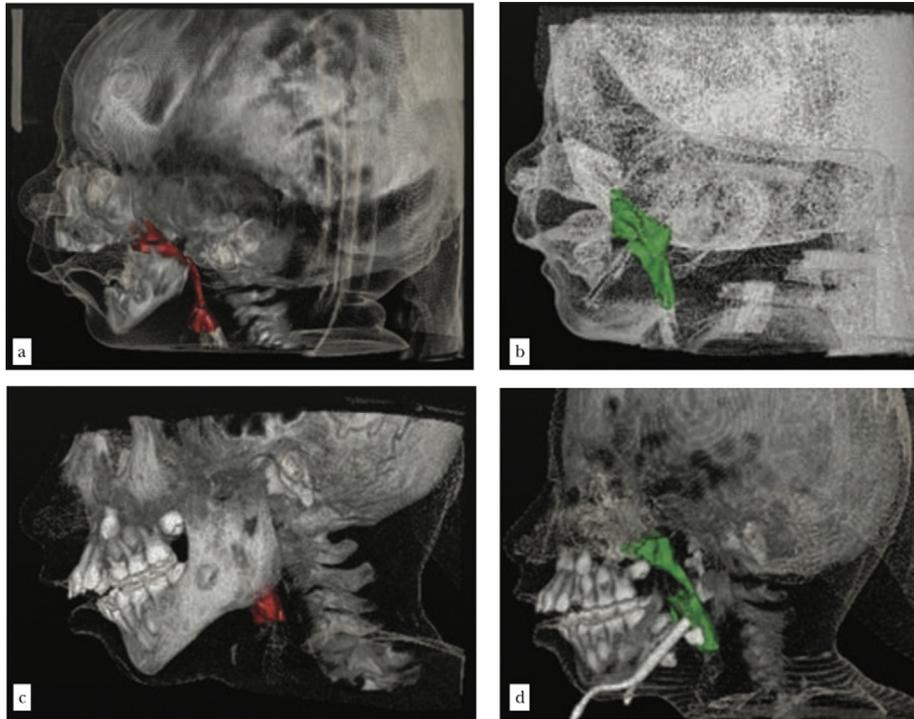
Patient number 3: (a) pre-operative and (b) post-operative virtual three-dimensional computed tomography scan showing soft tissue, skull, and airway reconstruction of a young boy affected by Crouzon syndrome, who experienced a post-operative upper airway volume gain of 28.586 mm³; patient number 6: (c) pre-operative and (d) post-operative virtual three-dimensional computed tomography scan showing soft tissue, skull, and airway reconstruction of a young boy affected by Crouzon syndrome, who experienced a post-operative upper airway volume gain of 24.510 mm³.
